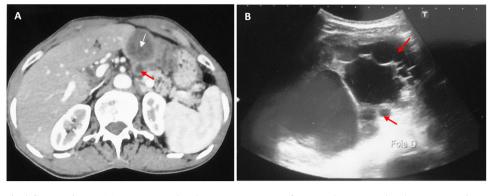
Axial abdominal CT scan image (a): exogenous daughter cyst appearing as a peripherally lined round lesion with fluid in the center with higher attenuation values than the mother cyst (red arrow) representing the daughter cyst sign of an exogenous daughter cyst. Endogenous daughter cyst appearing in the lumen of mother cyst with high-attenuation oval masses (white arrow) representing the daughter
